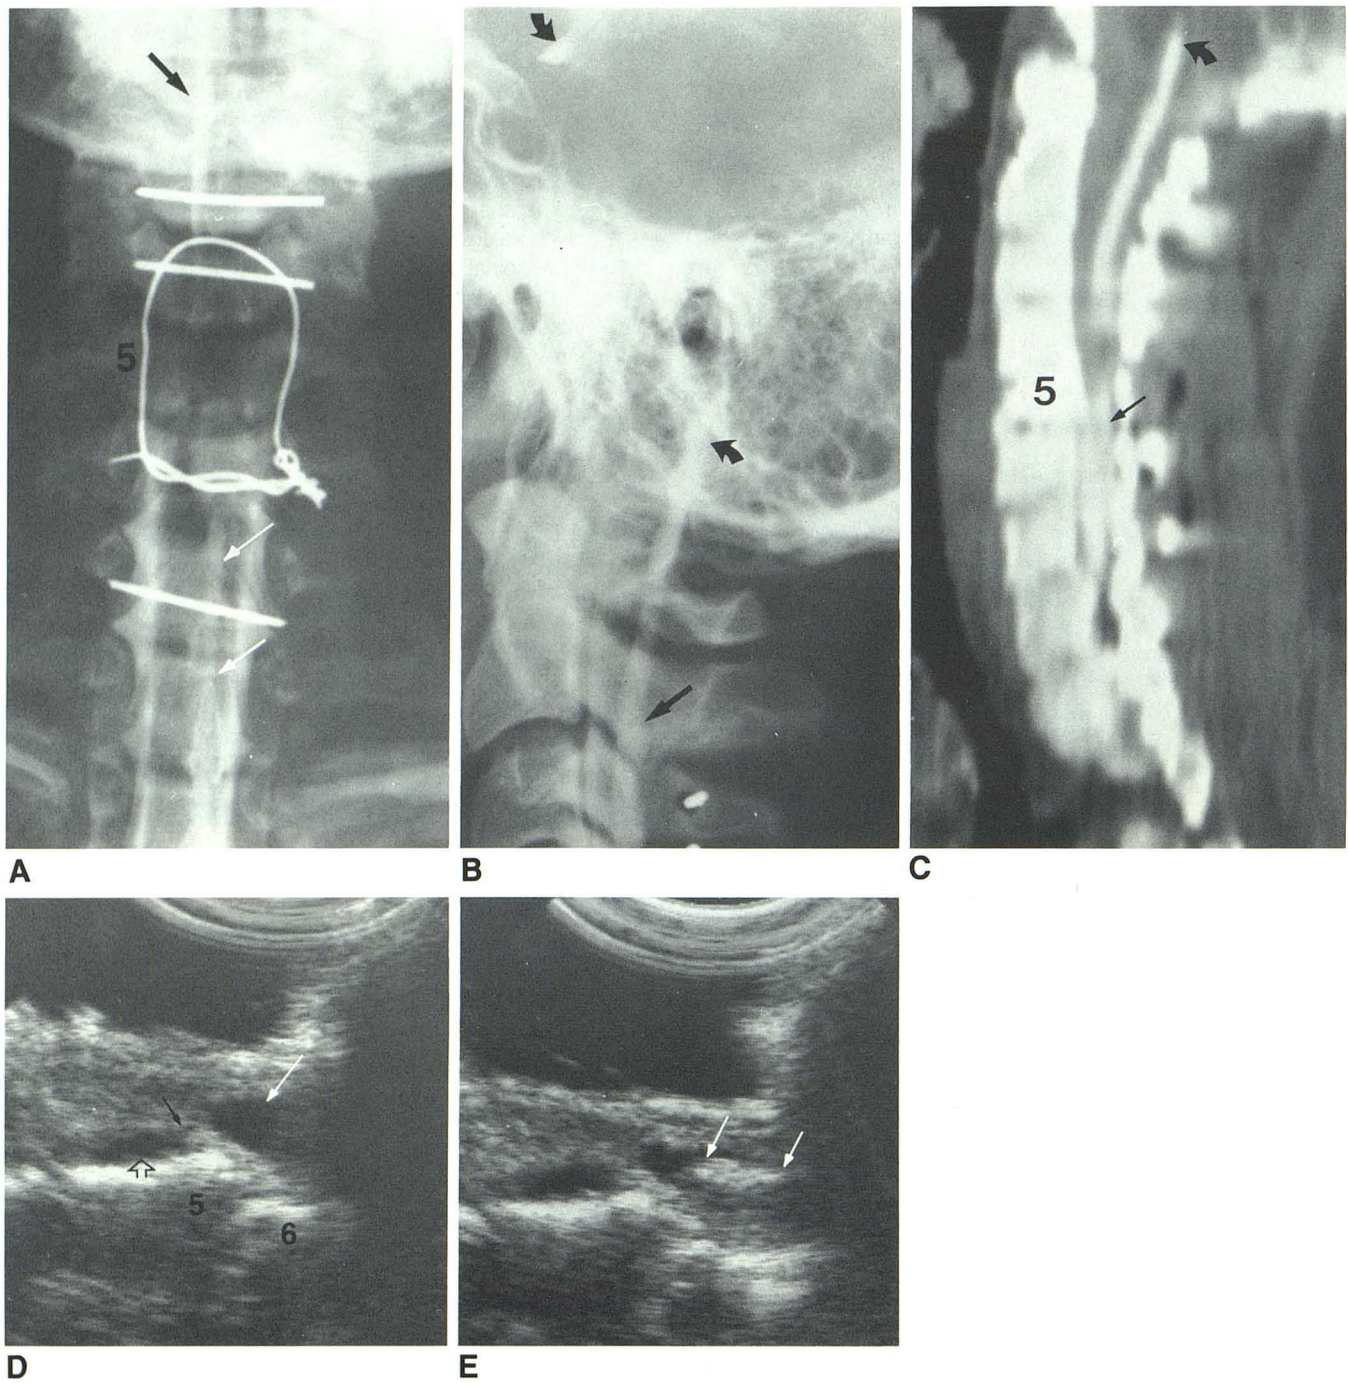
Early fluoroscopic spot film (not shown) during metrizamide myelogram from below showed contrast medium entering spinal cord at C5–C6 and extending further craniad. Later overhead AP (A) and lateral (B) films revealed passage of contrast medium from high cervical cord (straight black arrows) into medulla and ventricular system (curved arrows). Caudal extension (white arrows) into thoracic spinal cord was also seen. IMCT in axial and sagittally-reconstructed (C) views documented superior extension of contrast medium within cord from C5–C6 fracture-subluxation site (straight arrow) to high cervical cord and medulla (curved arrow) and showed its inferior extension to T4. D, Initial IOSS in sagittal projection at C5–C6 level showed that contrast medium within cord seen on myelogram and IMCT was secondary to sizeable cyst (white arrow) and that cord was tethered at this fracture-subluxation site. Fissure (solid black arrow) directly connecting cord cyst at C5–C6 to adjacent dilated subarachnoid sac (open arrow) was incompletely imaged on these static images but was well seen on real-time. Smaller superior extension of this cyst at C4 level, separated from larger part of cyst by myelomalacic cord, was shown on other images. E, Sagittal sonogram after placement of single shunt tube (arrows) confirmed collapse of cyst at C5–C6 level. Intraoperative scanning, however, also showed that this shunt tube could not be easily passed superiorly and that a second smaller shunt tube was needed to decompress cyst superiorly.
